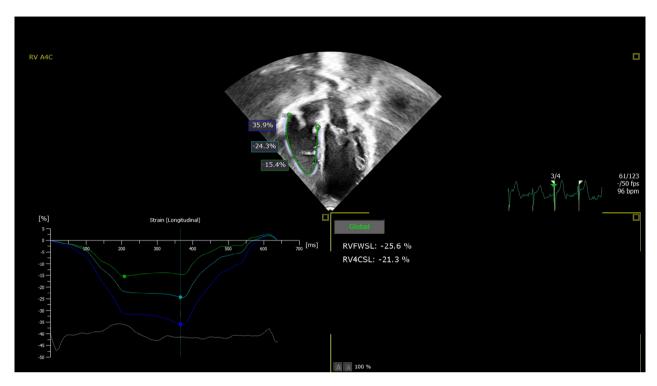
Shows RV global and segmental strain using 2D speckle tracking echocardiography before ASD device closure with right ventricular free wall longitudinal strain (RVFWSL)= 25.6%, right ventricular four chamber longitudinal strain (RV4CSL)=-21.3%, apical free wall longitudinal strain=-15.4%, mid-wall free wall longitudinal strain=-24.3%, basal free wall longitudinal strain=-35.9%.
